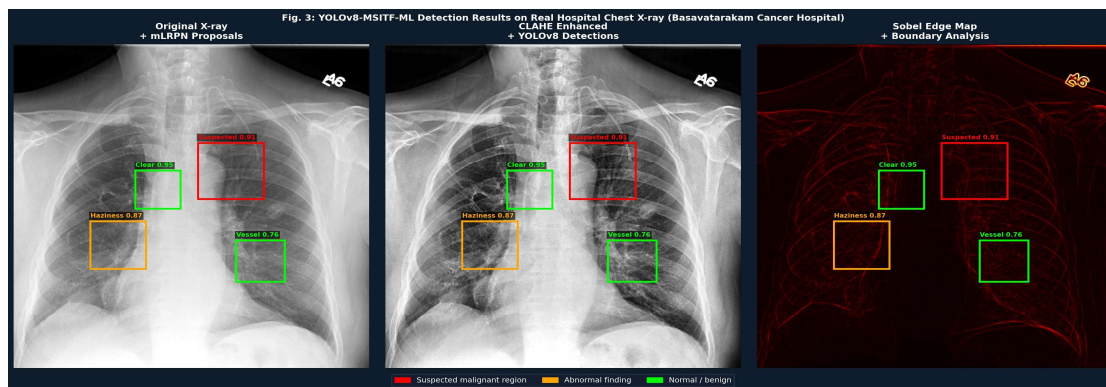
YOLOv8-MSITF-ML detection results on real hospital chest X-ray (Basavatarakam Cancer Hospital). Left: Original X-ray + mLRPN proposals. Centre: CLAHE enhanced + YOLOv8 detections. Right: Sobel edge map + boundary analysis. Red = suspected malignant; Orange = abnormal finding; Green = normal/benign.
